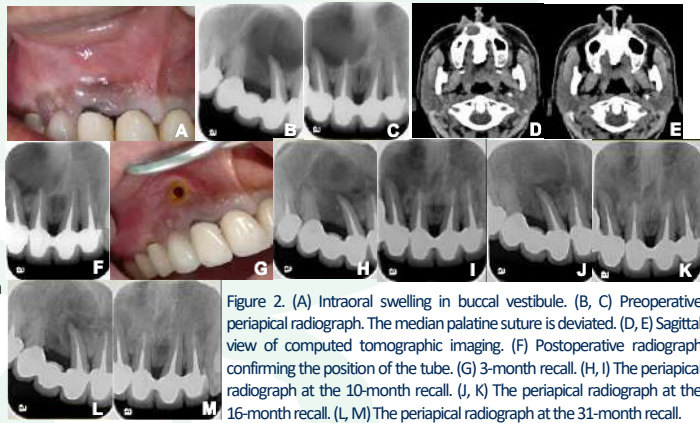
(A) Intraoral swelling in buccal vestibule. (B, C) Preoperative periapical radiograph. The median palatine suture is deviated. (D, E) Sagittal view of computed tomographic imaging. (F) Postoperative radiograph confirming the position of the tube. (G) 3-month recall. (H, I) The periapical radiograph at the 10-month recall. (J, K) The periapical radiograph at the 16-month recall. (L, M) The periapical radiograph at the 31-month recall.
